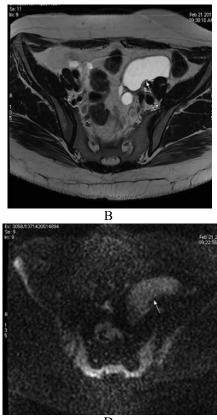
(A-F): Simple right adenxal cvst in a 44 year-old women (a) Unenhanced T1-weighted axial image.(b) T2-weighted axial image show a cyst at right ovary demonstrates clear fluid signal intensity.(c) Diffusion-weighted (b=1000 sec/mm2) show that, the cyst demonstrate hypointense signal (arrows) (d) Corresponding ADC map shows that the cyst demonstrates high signal intensity with high ADC value= 1.7×10^{-3} cm/s). (e,f) Graphs show the dynamic enhanced time-intensity curve for the selected ROI during the three-point dynamic run, shows slower and less intense enhancement than the myometrium suggesting benignity.
